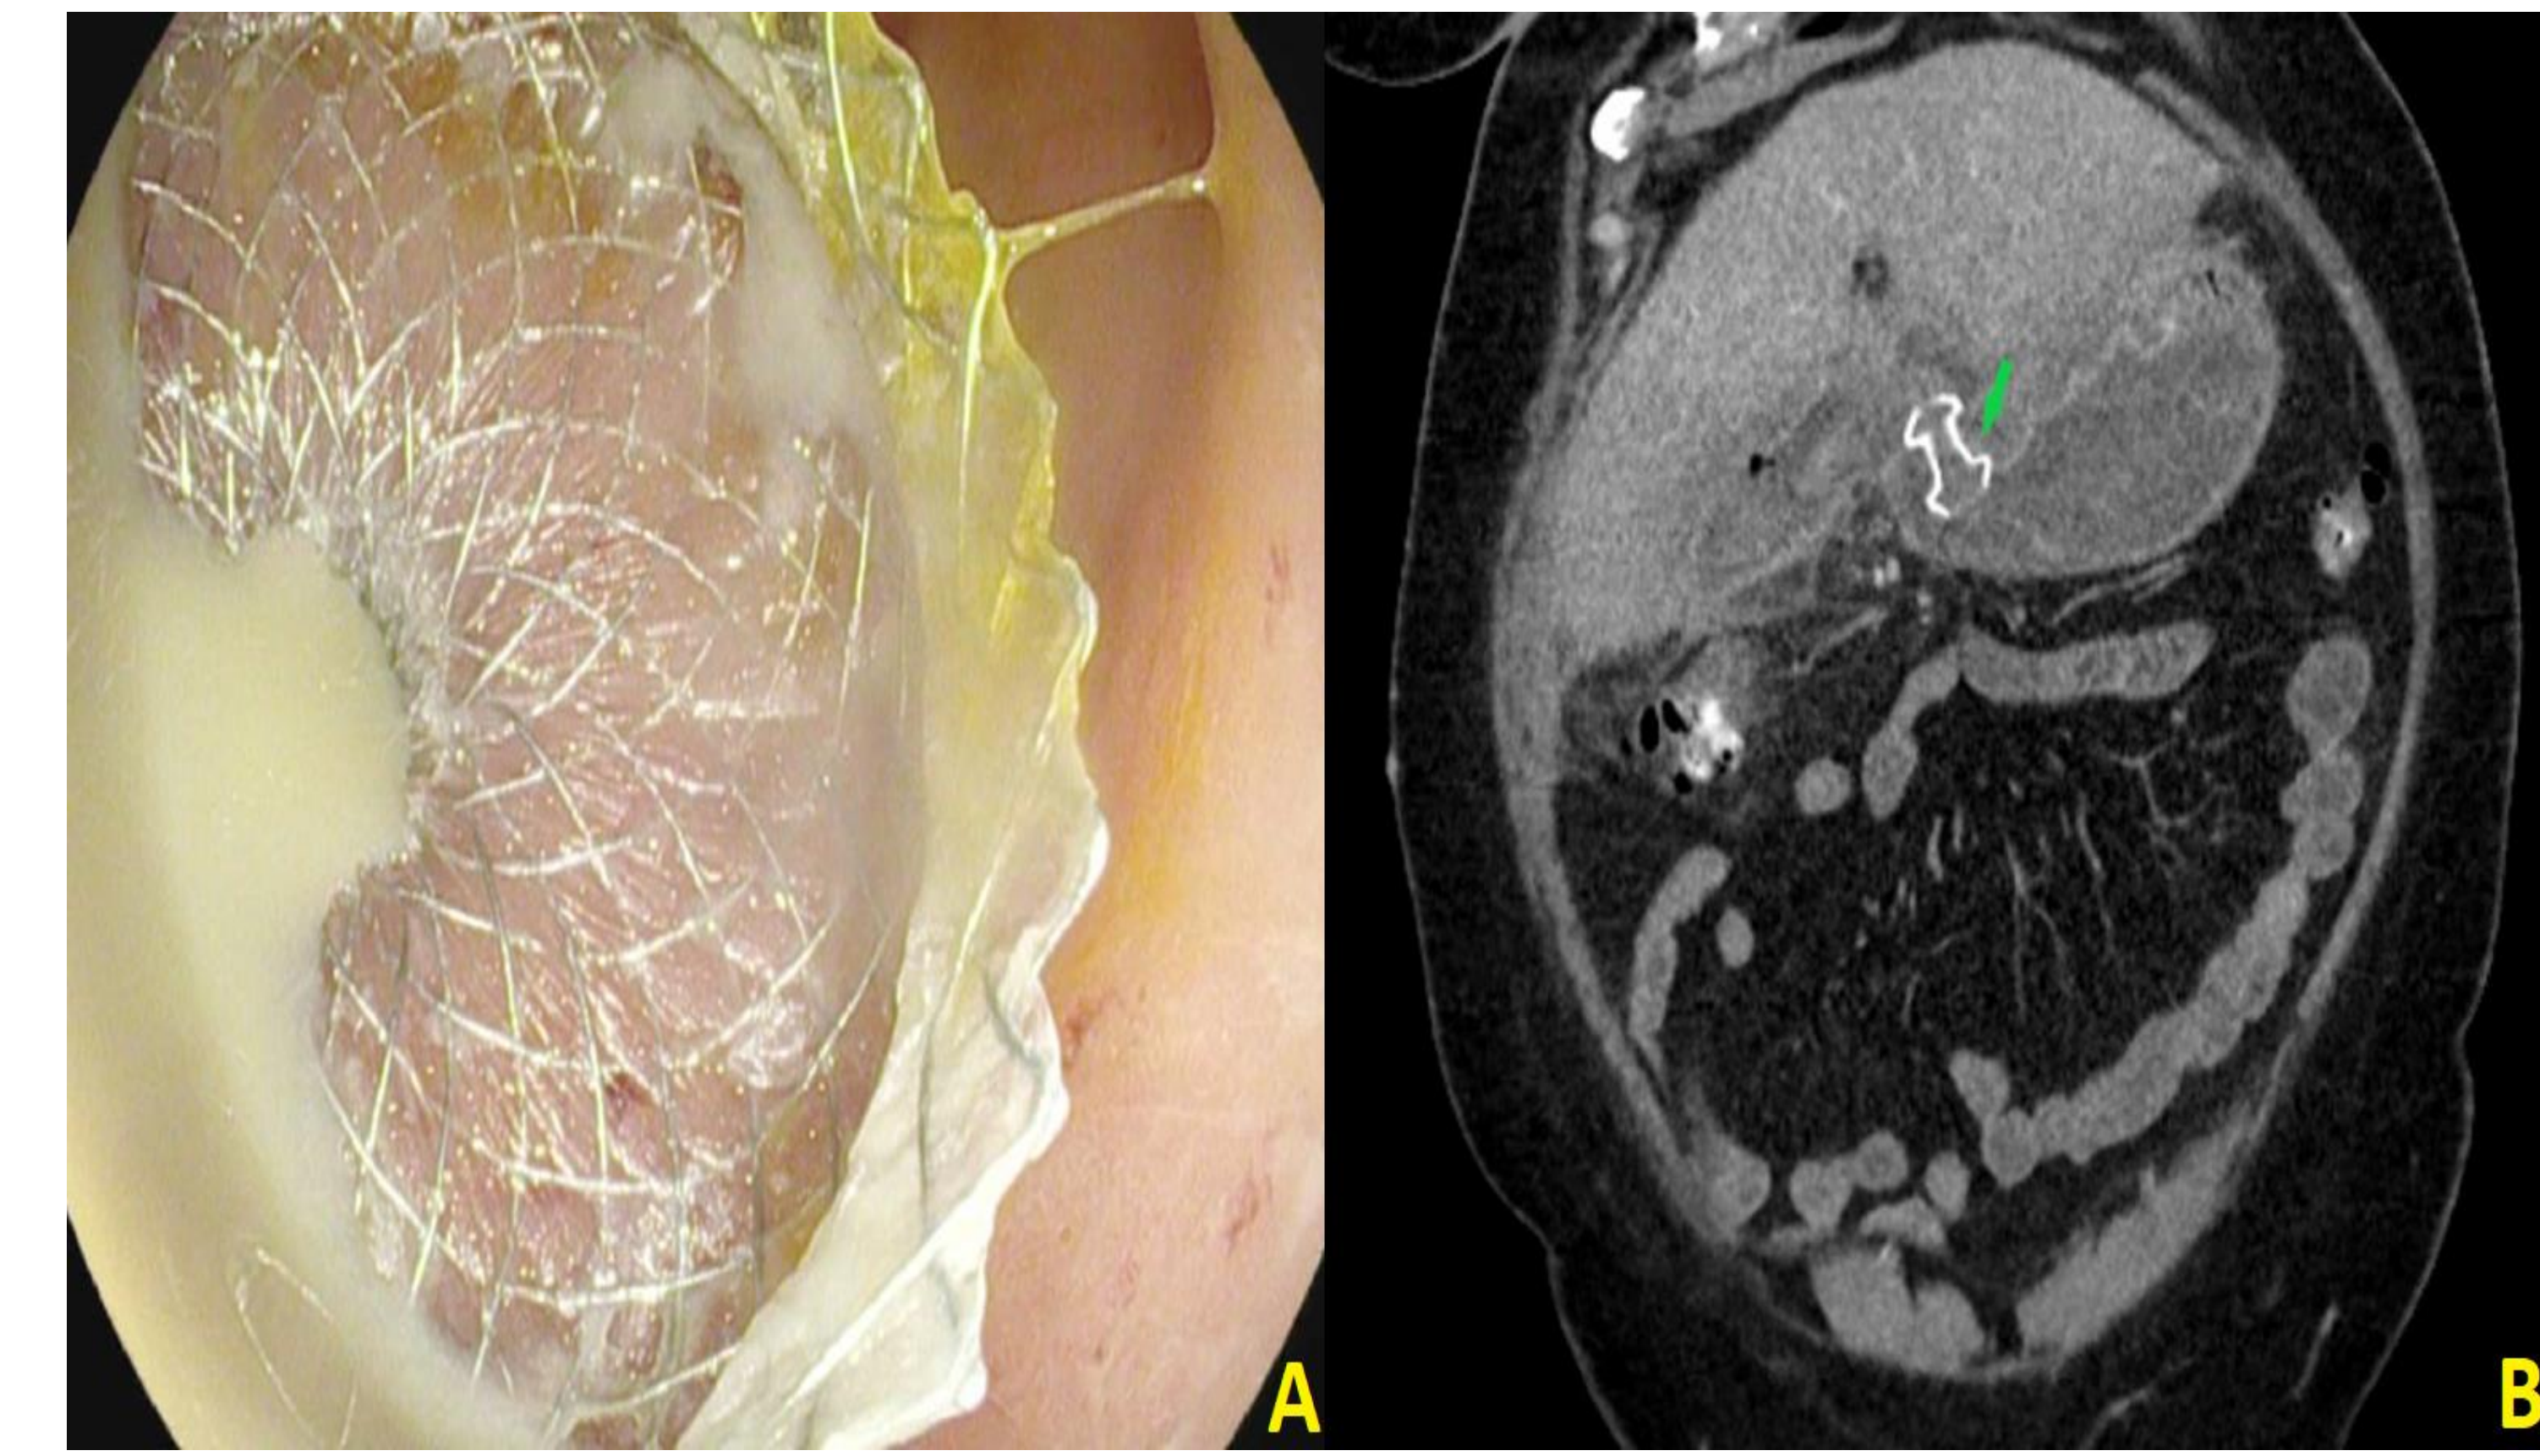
A) Successful placement of a transgastric lumen apposing metal stent (LAMS) into the biloma cavity with immediate drainage of purulent fluid. B) Post-drainage CT scan demonstrating biloma cavity decompression and appropriate positioning of the LAMS (green arrow).
